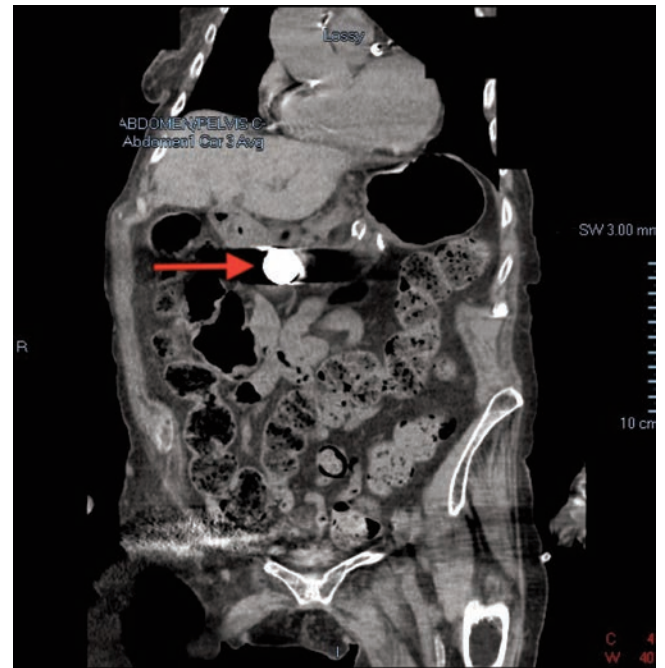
Computed tomography (coronal view) showing a foreign body within the stomach.
